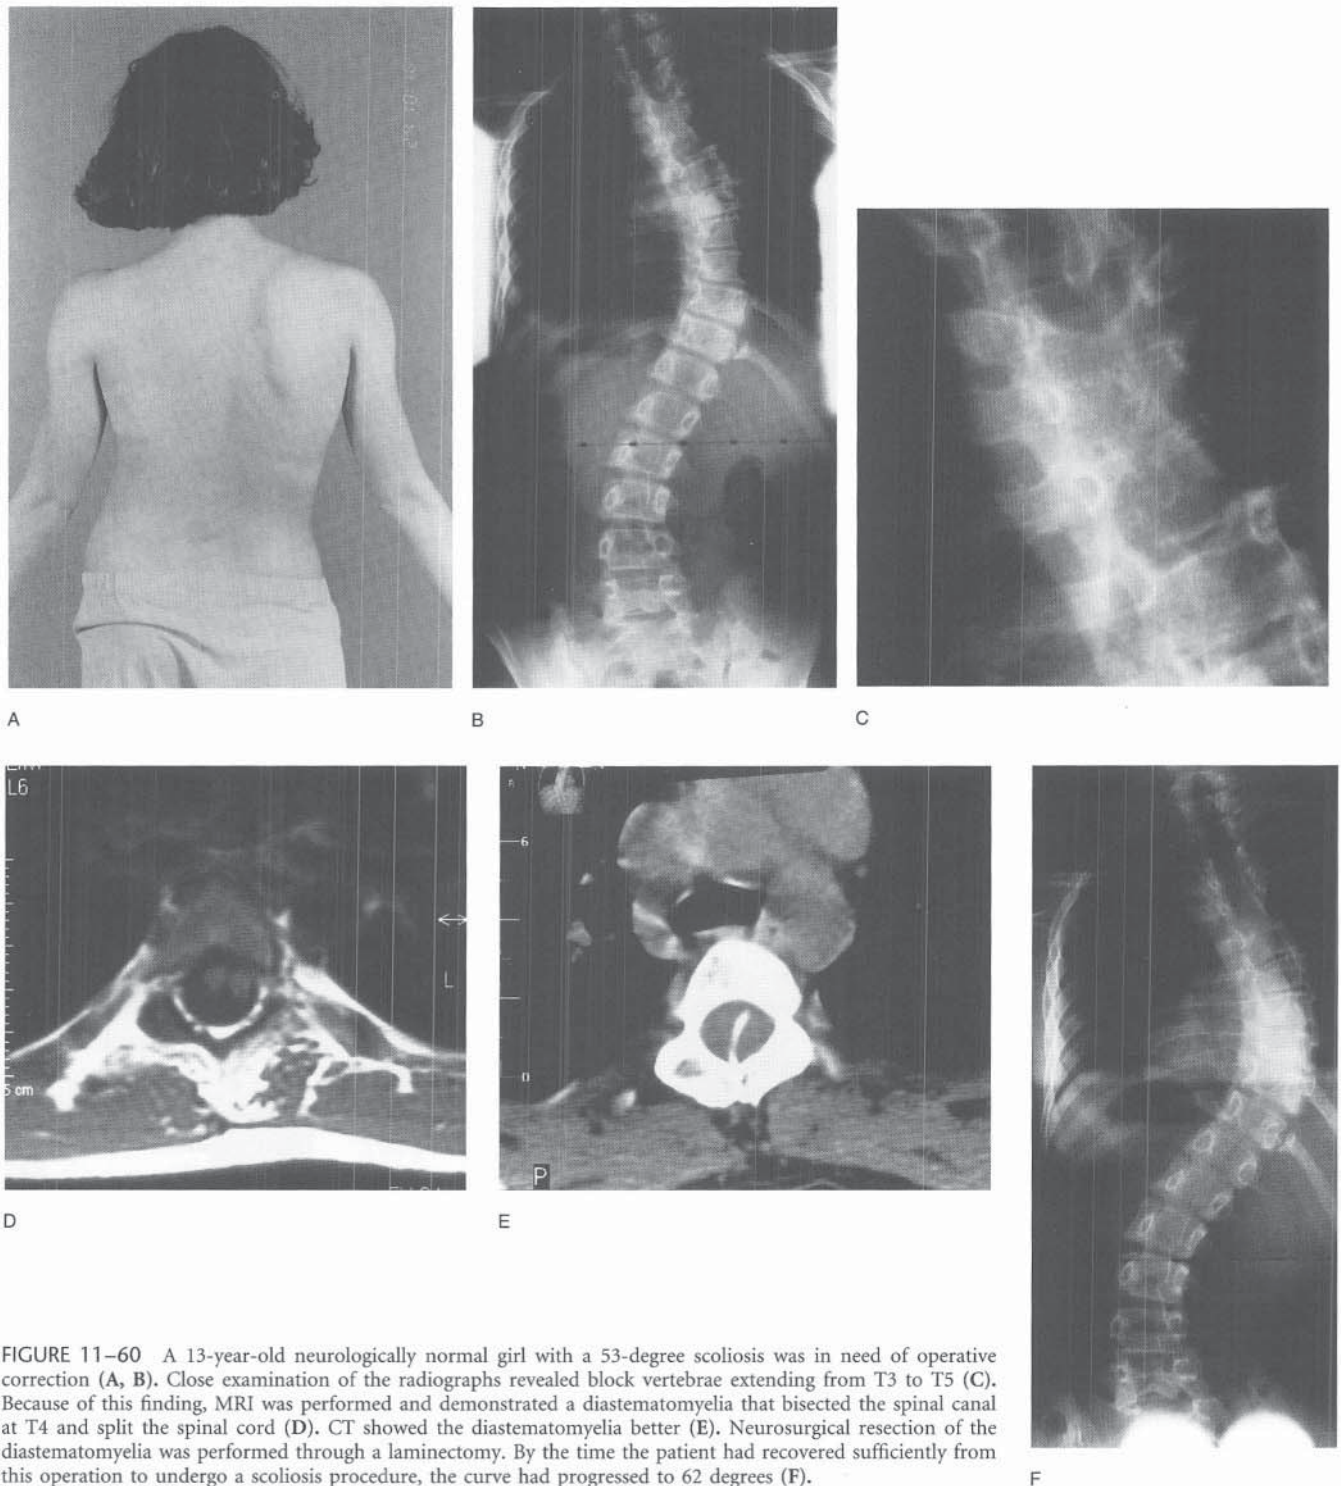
A 13-year-old neurologically normal girl with a 53-degree scoliosis was in need of operative correction (A, B). Close examination of the radiographs revealed block vertebrae extending from T3 to T5 (C). Because of this finding, MRI was performed and demonstrated a diastematomyelia that bisected the spinal canal at T4 and split the spinal cord (D). CT showed the diastematomyelia better (E). Neurosurgical resection of the diastematomyelia was performed through a laminectomy. By the time the patient had recovered sufficiently from this operation to undergo a scoliosis procedure, the curve had progressed to 62 degrees (F).
